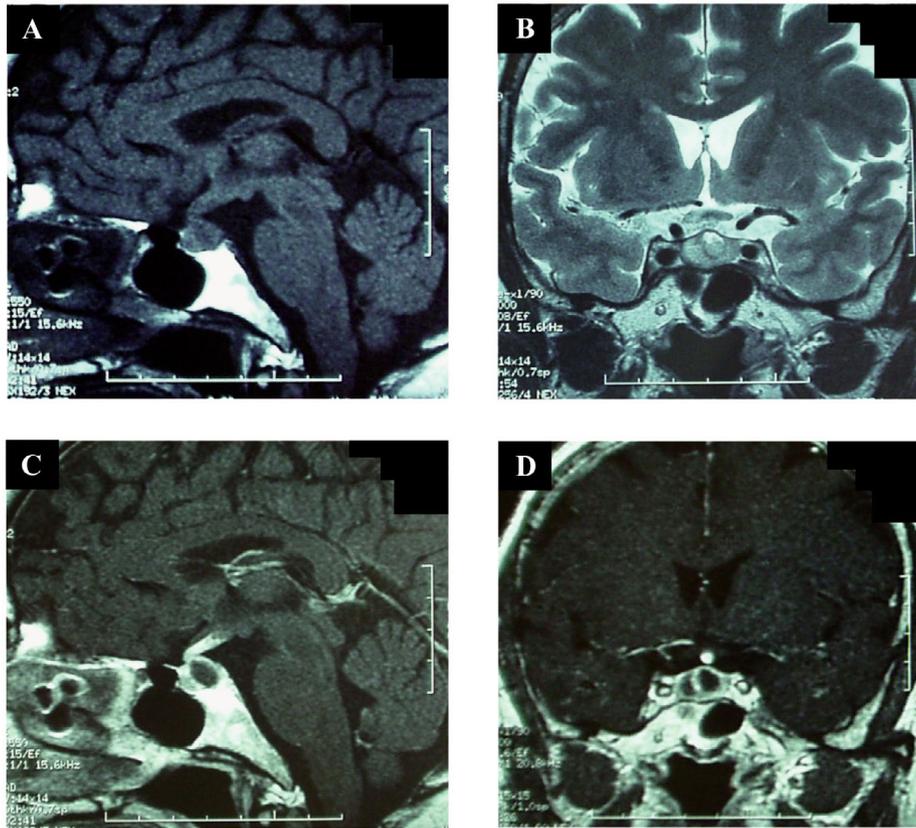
MRI of the pituitary gland on admission. (A) Sagittal T1-weighted imaging without gadolinium (Gd) contrast. Loss of the “bright spot” of the posterior pituitary gland was observed. (B) Coronal T2-weighted imaging without Gd contrast. (C) Sagittal T1-weighted imaging with Gd contrast suggested cystic enlargement of the pituitary gland with peripheral rim enhancement, and thickening of the pituitary stalk with homogeneous enhancement. (D) Coronal T1-weighted imaging with Gd contrast.
